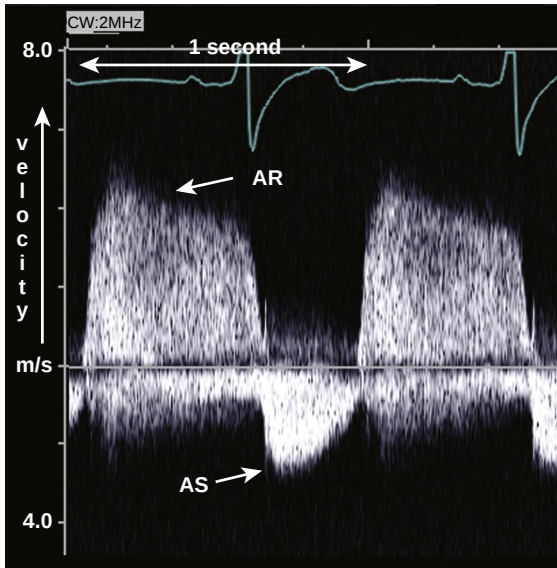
CW Doppler recording. The spectral recording of antegrade (aortic stenosis, AS) and retrograde flow (aortic regurgitation, AR) across the aortic valve shows time (horizontal axis in seconds), velocity (vertical axis in m/s), and signal strength (gray scale). High velocity flow can be measured without aliasing using CW Doppler, as shown in the aortic regurgitant velocity over 4 m/s in this example.
